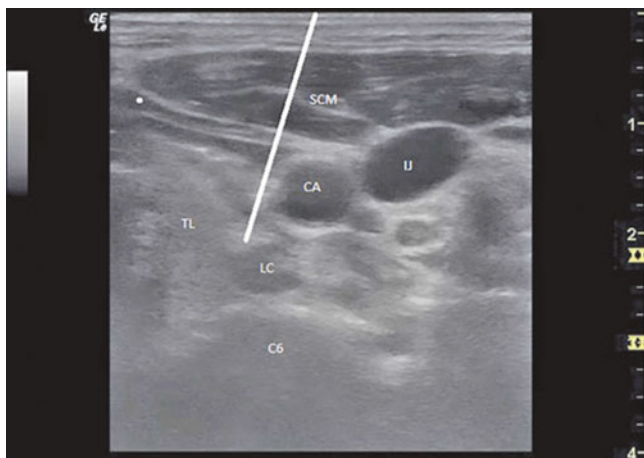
Ultrasound-guided approach to stellate ganglion block done at C6 level. *TL* thyroid lobule, *LC* longus colli muscle, *CA* carotid artery, *IJ* internal jugular vein, *SCM* sternocleidomastoid muscle
